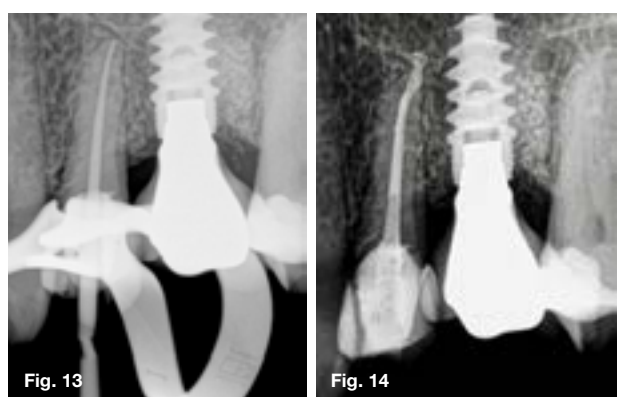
Cone-fit peri-apical radiograph. Note the loss of the apical curvature of the root canal system.
